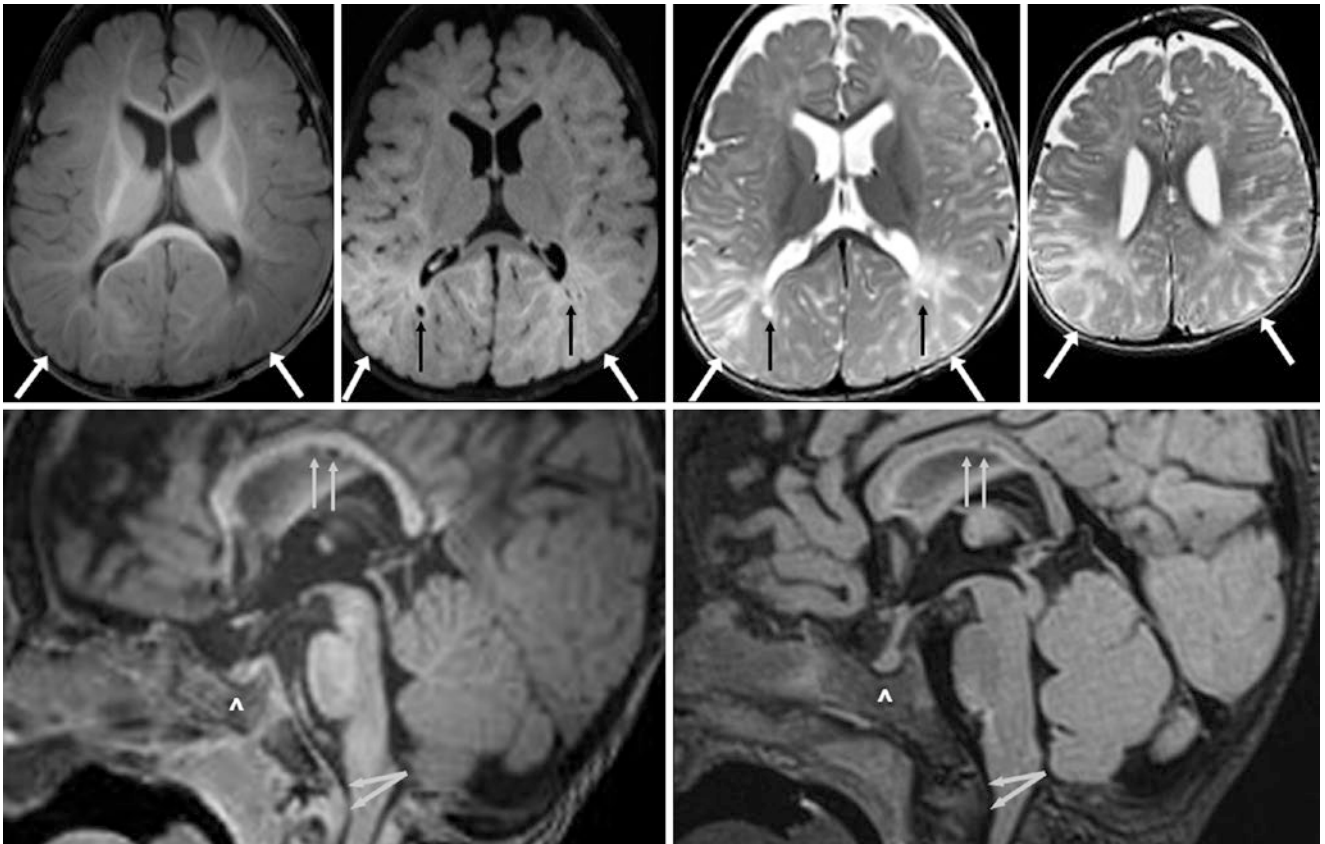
Comparison case of Hurler's mucopolysaccharidosis. A 9.5-month-old had abnormal deep WM and SCWM on a 3T MRI, with blurring of the gray-white junction (*arrows*) on GE T1WI (*top, left*), FLAIR (*top, left middle*), and SE T2WI (*top, right two images*). Typically, the posterior white matter is more mature, but the reverse is
